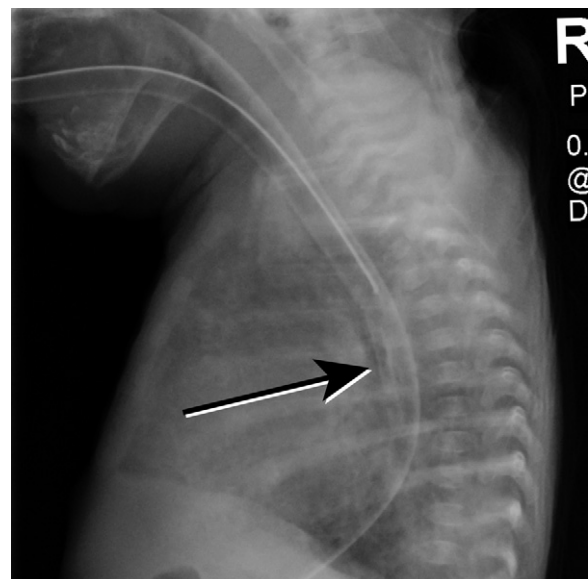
Lateral chest radiograph showing that the SCF is endobronchial (anterior to the nasogastric tube).
